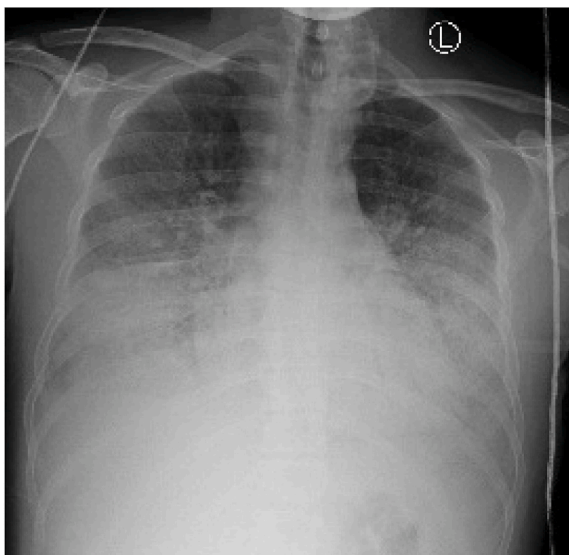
Chest X-ray Showing bilateral lung opacities.
